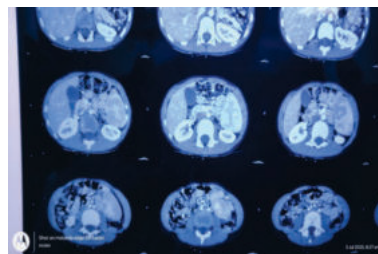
CT Angiography Suggestive of Wandering Spleen with Splenic Torsion and Infarction
